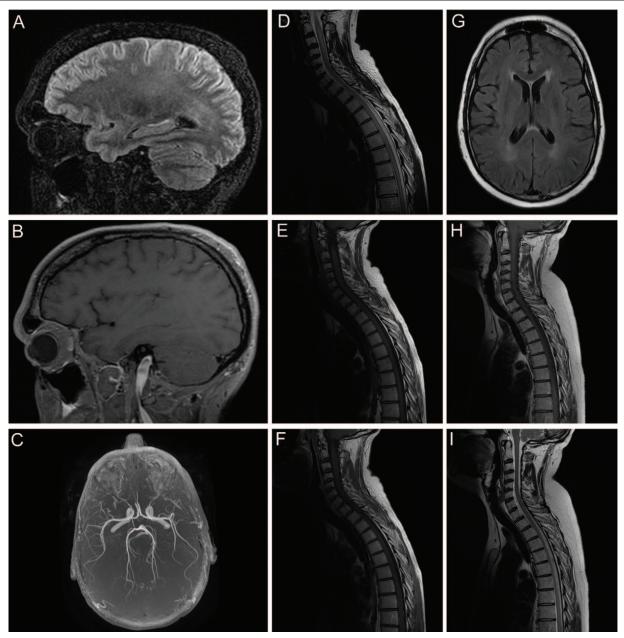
Head and medullary MRI show central nervous system lesions (case 1, Table 1). Head MRI showed a lepto-meningitis in sagittal cube-FLAIR sequences (A) and T1 FAT SAT sequences (B), with no vascular lesions in 3D TOF sequence (C). Medullary MRI revealed a centro-medullar pan-myelitis in sagittal T2 sequence (D), T1 FSE (E), and T1 FSE with gadolinium injection (F). After 1 year, a new head MRI uncovered an atypical leucopathy affecting the fornix, the corpus callosum, and centrum semiovale in axial T2 FLAIR sequence (G) and persistence of a pan-myelitis in sagittal T1 FSE (H) and T2 sequence (I). MRI=magnetic resonance imaging; FAT SAT=fat saturation; FLAIR=fluid attenuated inversion recovery; FSE=fast spin echo; TOF=time of flight.
